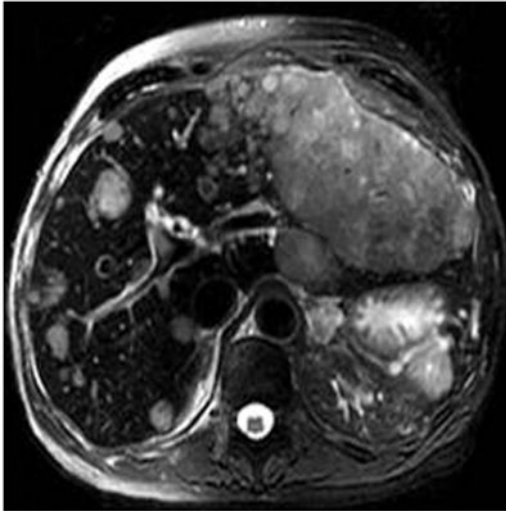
Multifocal HCCs well demonstrated using superparamagnetic iron oxide particle imaging. A T2-weighted image following SPIO administration shows a large mass in the left lobe and multiple smaller lesions in the right lobe.
